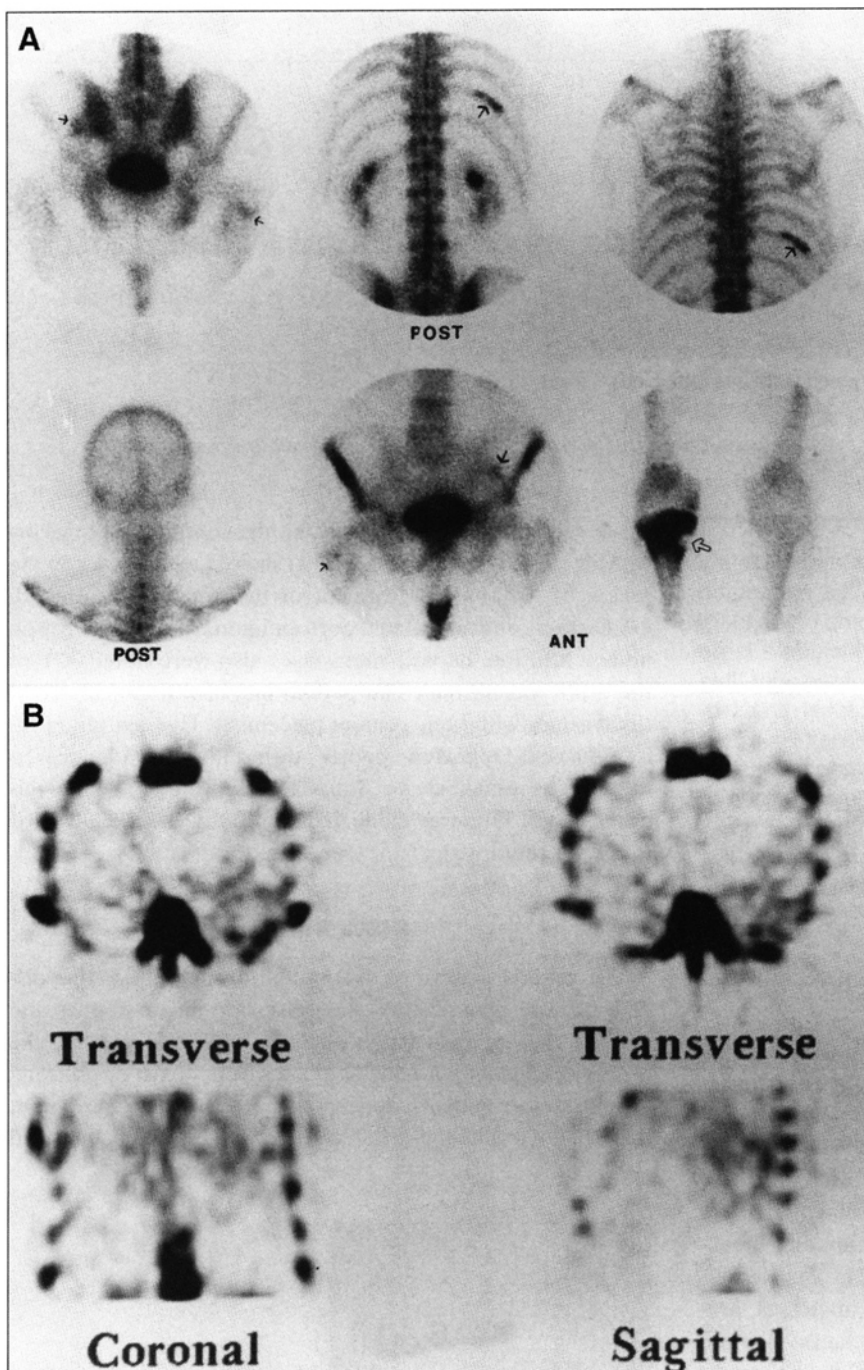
(A) Bone images show focal areas of increased uptake (arrows) in the left ileum, in a segment of a right lower rib, a small focal area of uptake in the right femoral neck, and marked increased uptake with a cold area, as indicated by an open arrow, in the right proximal tibia. No abnormal area of increased uptake in the cervical, thoracic and lumbar vertebrae is noted. (B) Technetium-99m HMDP bone SPECT images of the thorax show a faint increase in uptake in the left posterior thorax.
